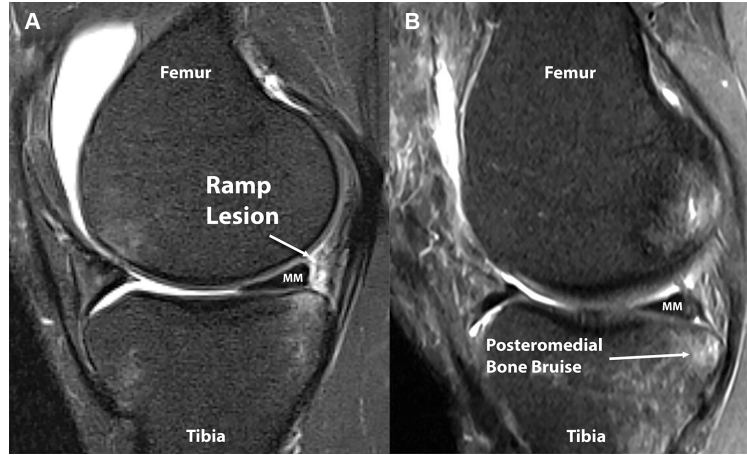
Preoperative magnetic resonance image (MRI) demonstrating meniscal ramp lesion and associated posteromedial tibial bone bruise pattern, best visualized on sagittal fat-saturated, T2-weighted images. (A) Meniscal ramp lesion, indicated by an increase in signal intensity at the peripheral margin of the posterior horn of the medial meniscus at the meniscocapsular junction. (B) Posteromedial tibial bone bruise and posterior medial meniscal contusion present on preoperative MRI in a patient with a combined anterior cruciate ligament tear and meniscal ramp lesion diagnosed at the time of arthroscopy. MM, medial meniscus.
